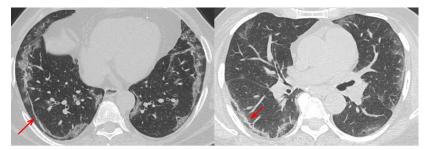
CT scan signs of Covid-19 - thin and thick bands. Axial images show thin (left image) and thick (right image) bands (red arrows), which occur typically after the 2nd week and represent edematous lung subtending areas of hypoperfusion.
